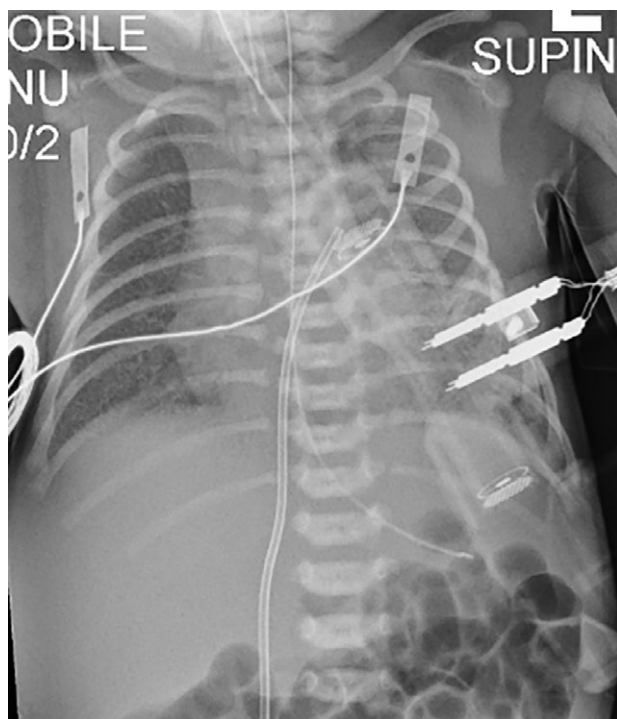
First chest X-ray after intubation.
